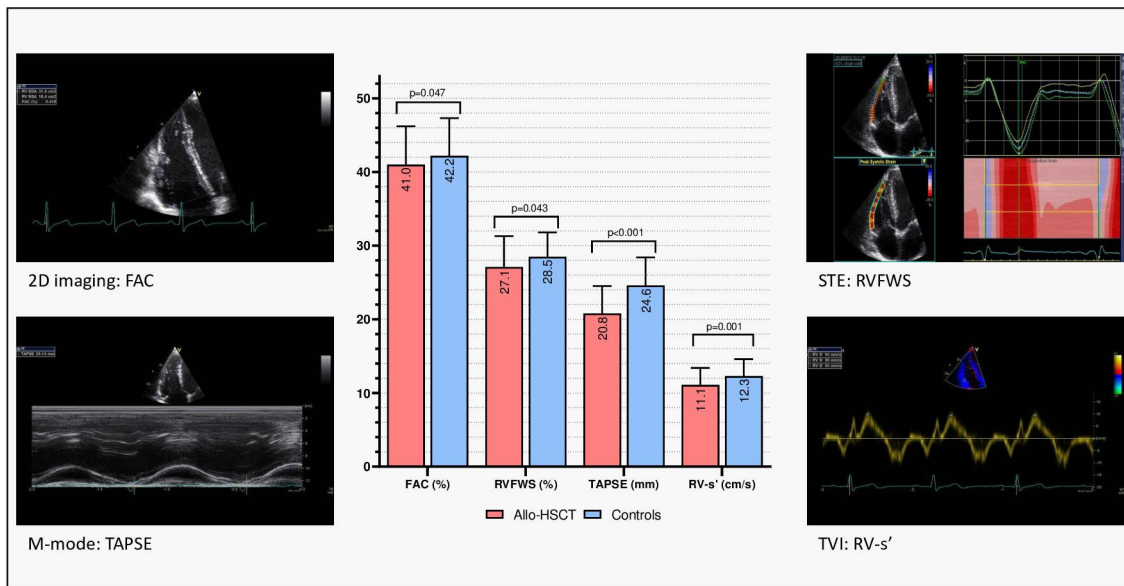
Comparison of right ventricular systolic function between allo-HSCT survivors and healthy controls. Presented with means±SD and adjusted p values. 2D, two dimensions; allo-HSCT, allogeneic haematopoietic stem-cell transplantation; FAC, fractional area change; M-mode, motion-mode ultrasound; RVFWS, Right ventricular Free-Wall Strain (absolute value), RV-s', right ventricular peak systolic velocity; STE, speckle tracking echocardiography; TAPSE, tricuspid annular plane systolic excursion; TVI, tissue velocity imaging.
